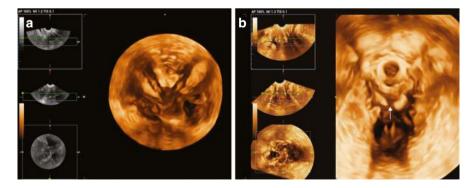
(a) A 3D ultrasound image of the uterus reveals the presence of two uteruses and two cervixes. (b) A 3D ultrasound image of the vagina shows an interrupted vaginal gas line, indicated by an arrow
